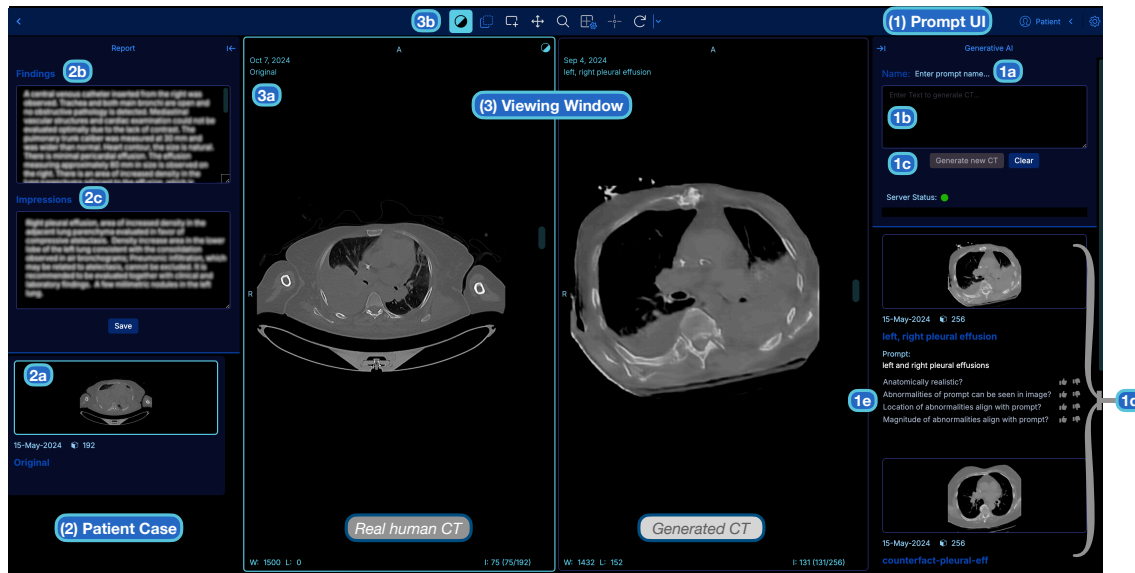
Open-sourced medical imaging interface by Ziegler et al. (2020) with our GenAI plugin powered by MedSyn (Xu et al. 2024). (2) Patient Case. The first column shows a real case consistent with severe right pleural effusion (sampled from CT-RATE dataset (Hamamci et al. 2023, 2024; Hamamci, Er, and Menze 2024)). (3) CT Scan Viewing Window. The second and third columns show a CT scan comparison viewing window, where a human’s CT scan (from (Hamamci et al. 2023, 2024; Hamamci, Er, and Menze 2024)) is on the left, and a generated CT scan from MedSyn (Xu et al. 2024) is on the right. (1) Prompt UI. The fourth column is our text-to-CT Scan GenAI plugin, allowing users to generate a CT scan.
